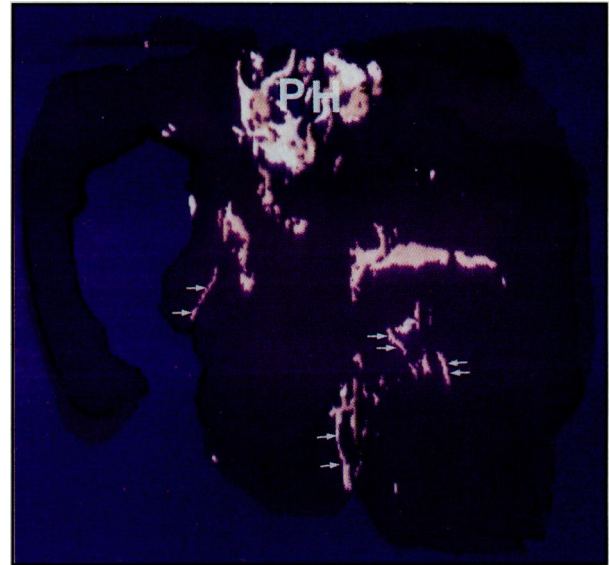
A coronal MR image demonstrating the periportal lymphatics (black arrows), marginal lymphatics (white arrow), portahepatis (PH), and hepatic veins (V).
